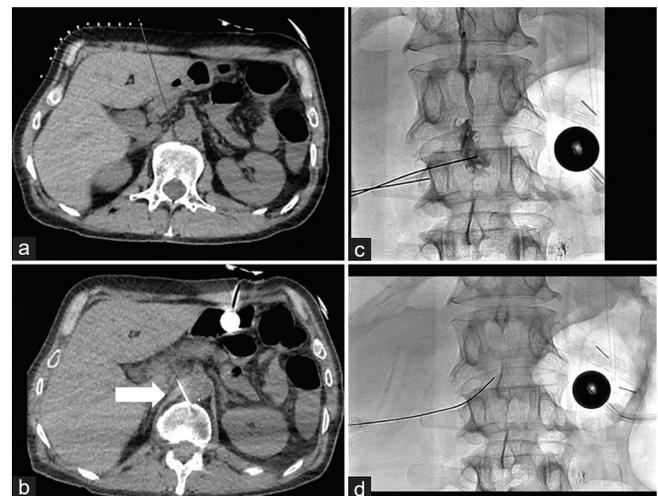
(a) Localizer function marks trajectory of needle. (b) Real-time computed tomography confirms needle positioning (arrow) and prevents potential collateral injury. (c) Quick transition to fluoroscopy facilitates contrast injection to verify lymphatic access. (d) Wire advanced within the thoracic duct
